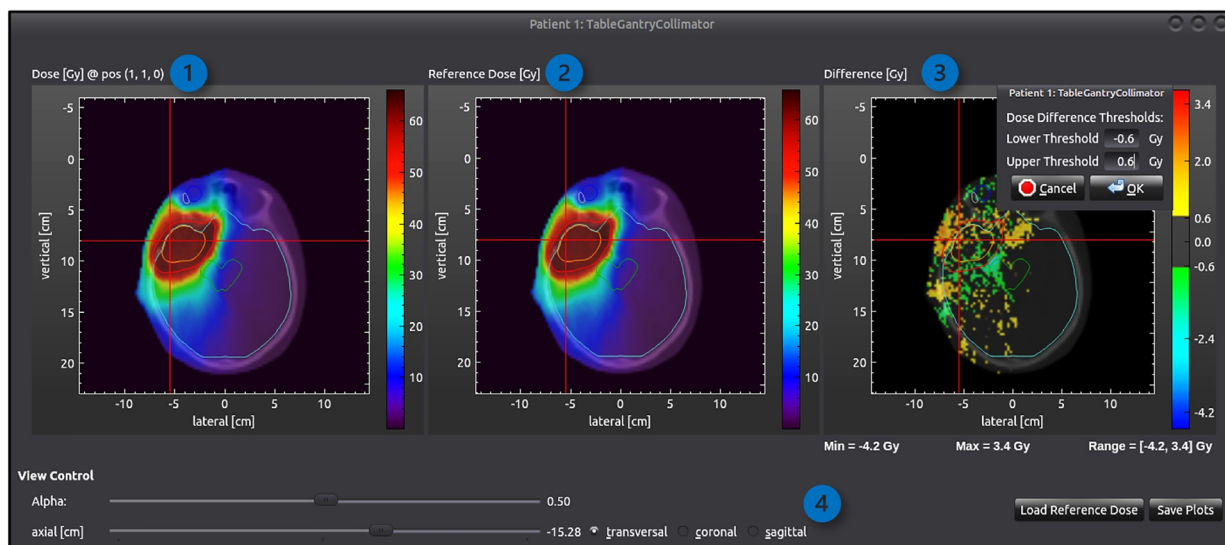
The dose window (opened by Figure 3, number 6) displays dose distributions superimposed on the CT. Structures are indicated by the fine lines (PTV and CTV in red and orange here). 1: Dose of current scenario. 2: Reference dose. 3: Dose difference between reference and current doses, includes a user-defined threshold to visualize relevant dose ranges. 4: View control to switch through transversal, coronal, and sagittal planes. The red cross serves as a guideline when switching planes from transversal (shown here) to coronal or sagittal
